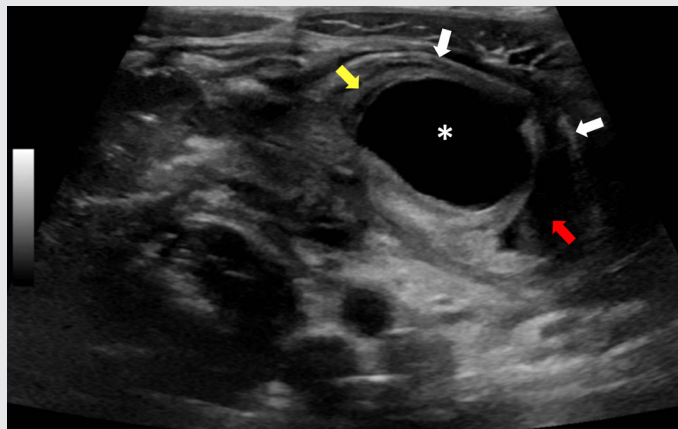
Abdominal ultrasound of a 3.1 cm intraluminal cystic structure. The structure has an anechoic center (asterisk) surrounded by a hyperechoic wall (yellow arrow) and lies within a bowel lumen (red arrow). The bowel wall is also observed (white arrows).
